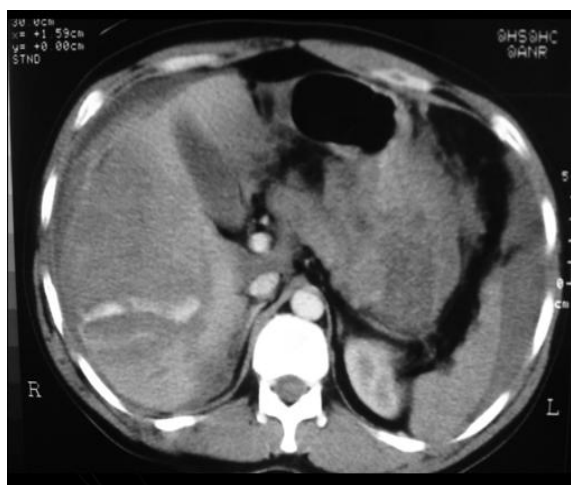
Axial computed tomography scan showing LIS grade IV liver injury secondary to being gored by a bull (Case 18).
